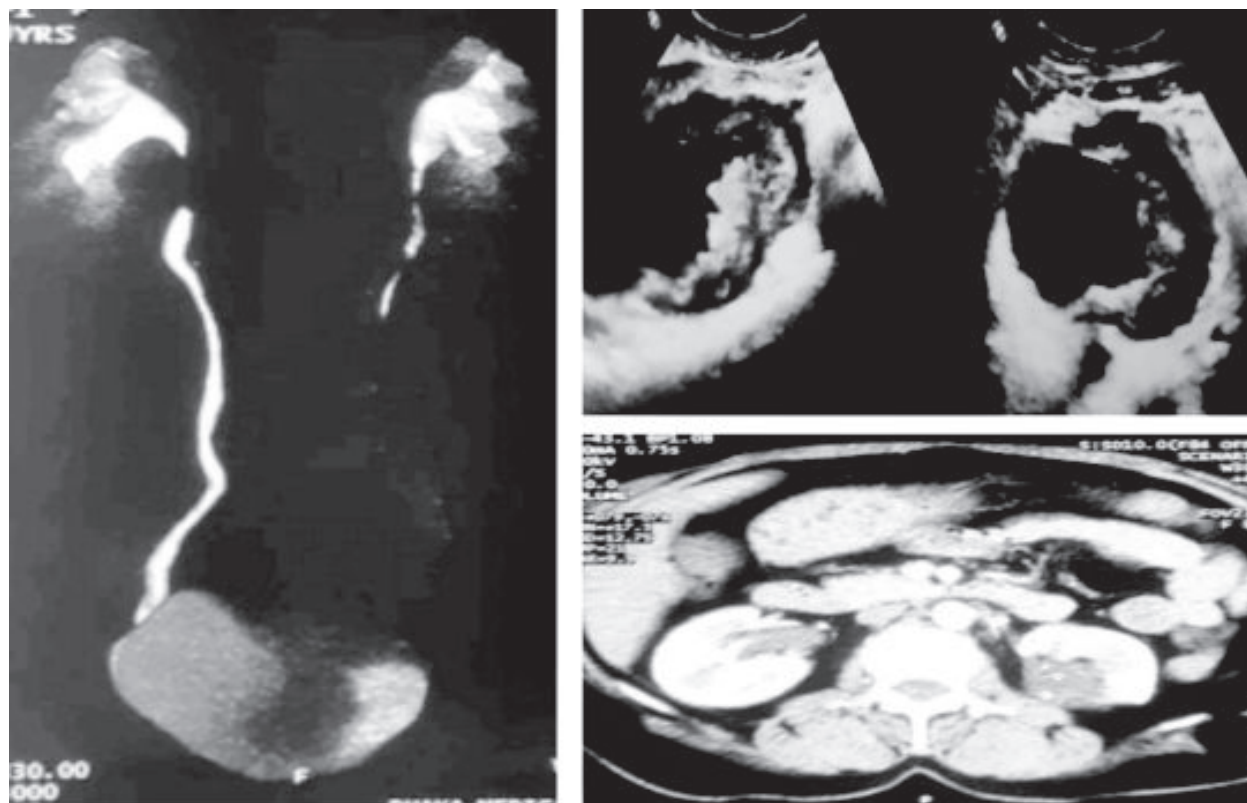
(Left top image): USG shows the mass well delineated as CT with its effect on kidney & ureter, Fig 5b (Right image): showing pre-contrast coronal image and Fig 5c (Left bottom image): showing enhancing urinary bladder mass with left sided VUJ obstruction resulting in marked hydroureteronephrosis.
